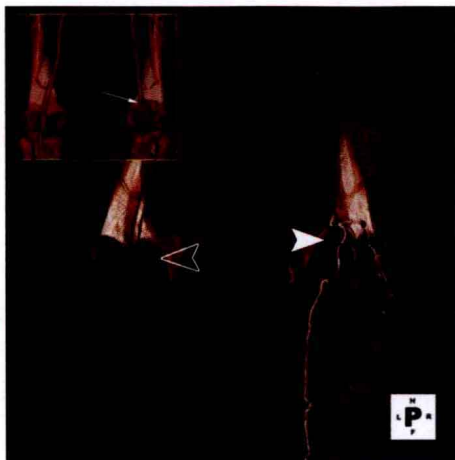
Popliteal artery entrapment. Three-dimensional CTA volume-rendered image (*posteroanterior view*) of a young patient with right calf pain on exertion. The medial head of the right gastrocnemius muscle demonstrates an abnormal origin lateral to the popliteal artery (*closed arrowhead*). *Inset* image shows complete occlusion of the right popliteal artery (*arrow*) with multiple superficial collateral arteries originating just proximal to this level. The normal origin of the medial head of the left gastrocnemius medial to the popliteal artery (*open arrowhead*) is shown for comparison. (Reprinted from Cohen E, Doshi A, Lookstein R. CT angiography of the lower extremity circulation with protocols. In: Mukerjee D, Rajagopalan S, eds. *CT and MRI angiography of the peripheral circulation: practical approach with clinical protocols*. London, UK: Informa Health Care, 2007:143, with permission.)
